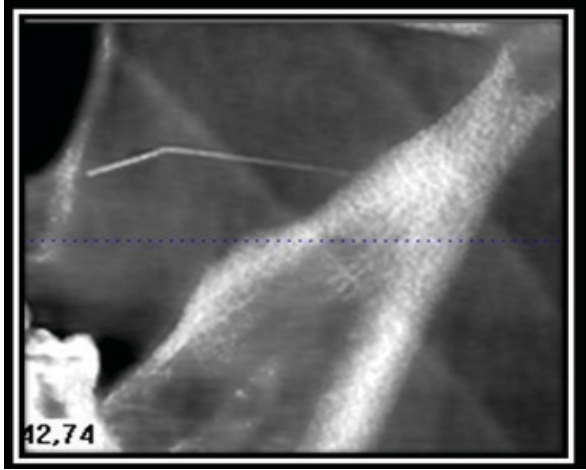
CBCT view of the broken segment
